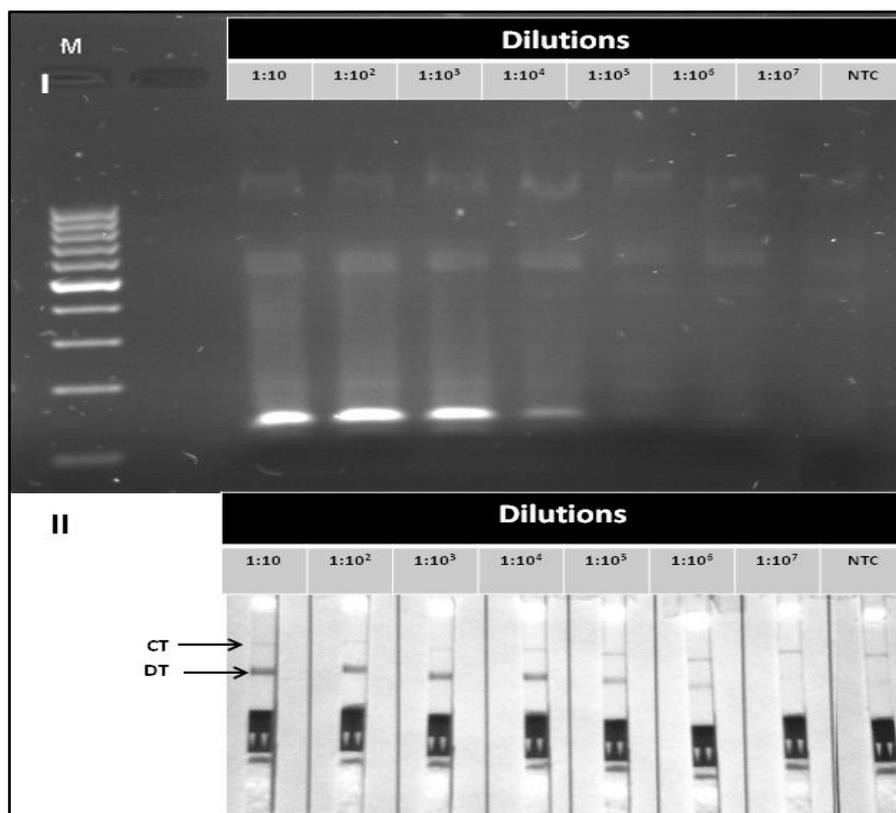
Figure C-1. Sensitivity of two-step lateral flow strip-RPA assay (LFS-RPA assay) for the detection of the 10-fold serial dilution of Yellow Fever virus RNA. I) Sensitivity of LFS-RPA assay as observed by 115 bp amplicon on 1.5 % gel by gel electrophoresis. II) Sensitivity of LFS-RPA assay as observed by detection line on LFS. CT: control line, DT: detection line.
